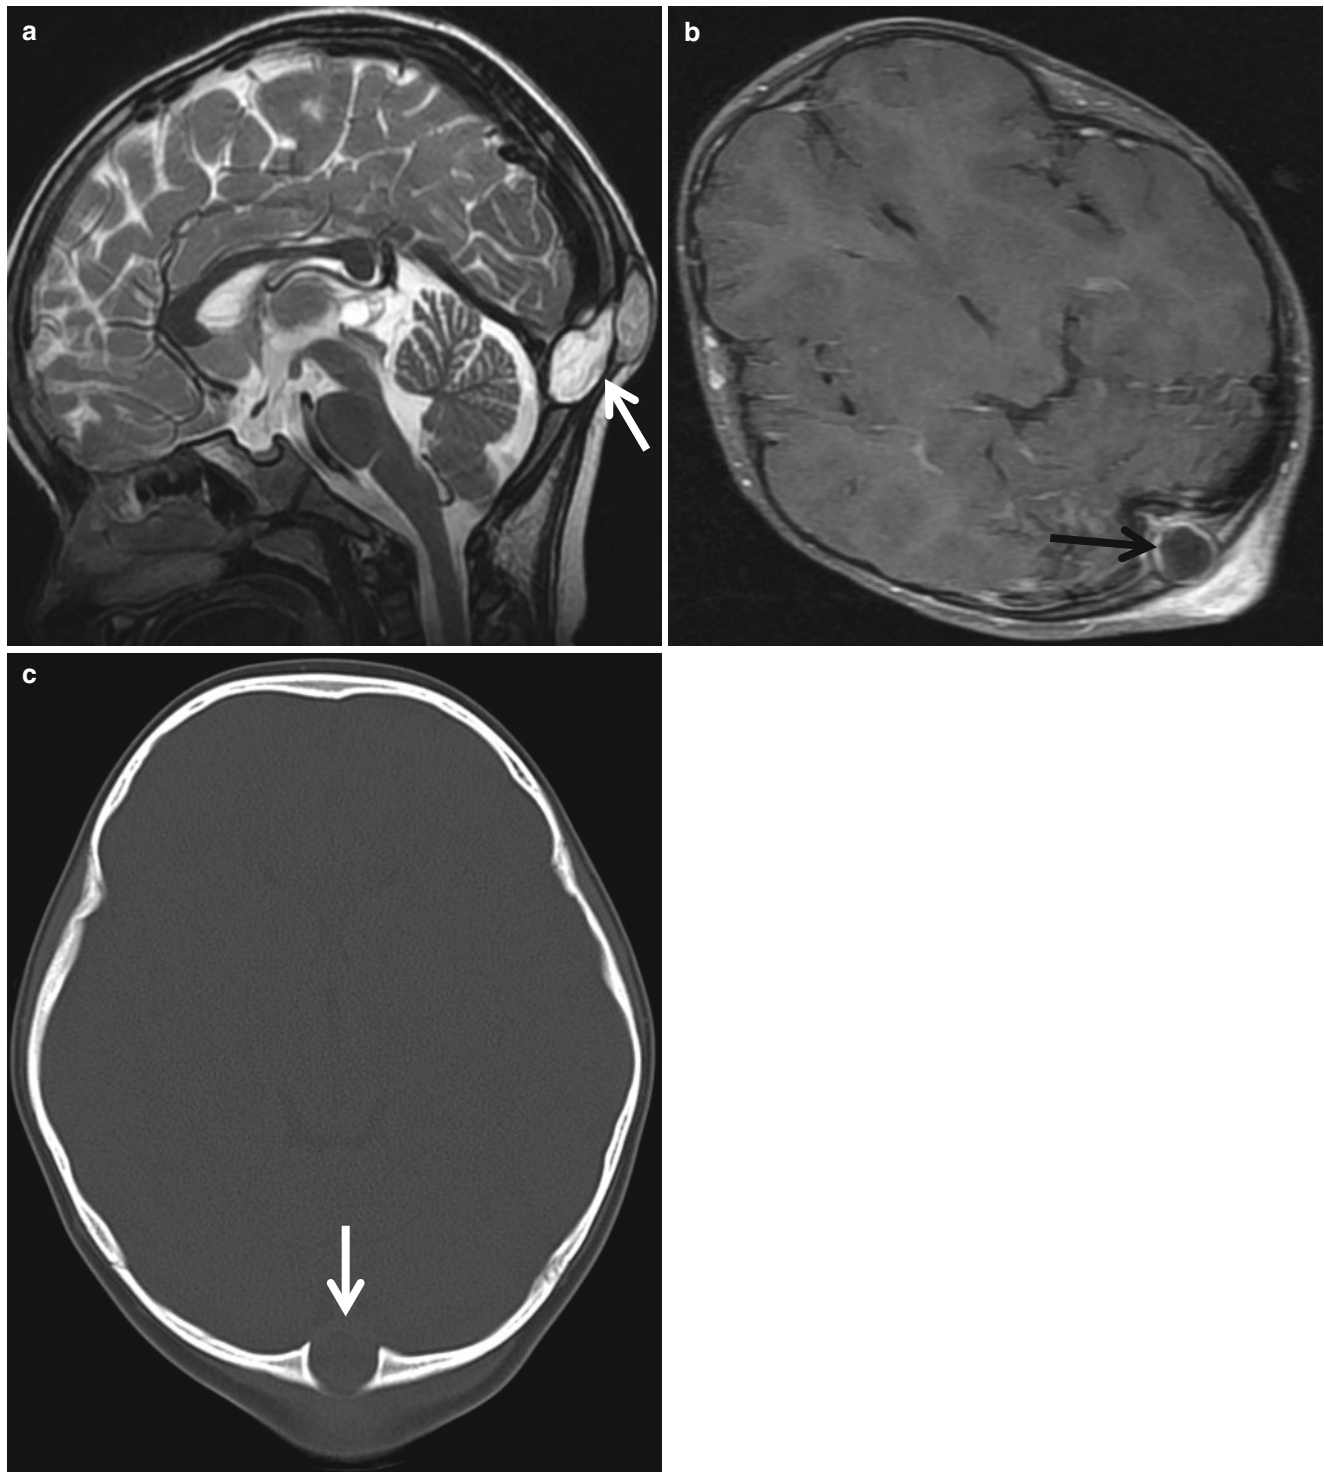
Infected dermoid cyst. (a) T2-weighted sagittal image shows midline posterior cysts (*arrow*) involving both soft tissue in the scalp and occipital skull. (b) The cystic wall is enhanced (*arrow*), and more
